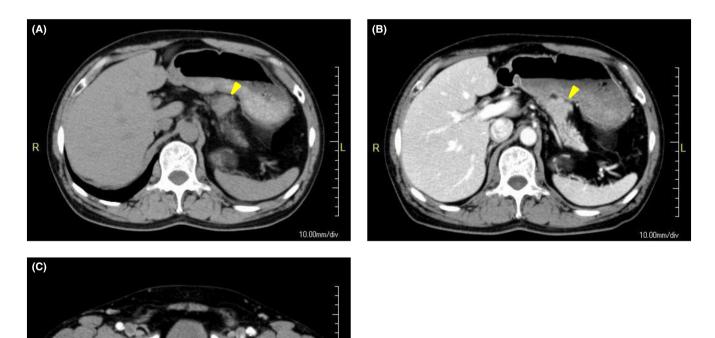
Abdominal computed tomography (CT) images. (A,B) The pancreatic tumor was observed (arrowhead) on plain CT (A) and contrast-enhanced CT (B). The tumor was demonstrated as a slightly contrast-enhanced lesion in pancreatic body. (C) The bone lesion was revealed as soft tissue behind the left iliac bone on contrast-enhanced CT.
